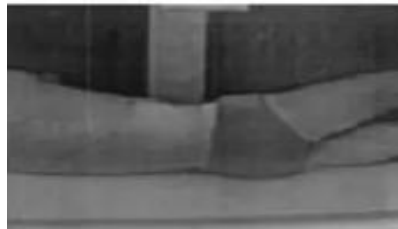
PA Radiography Results
